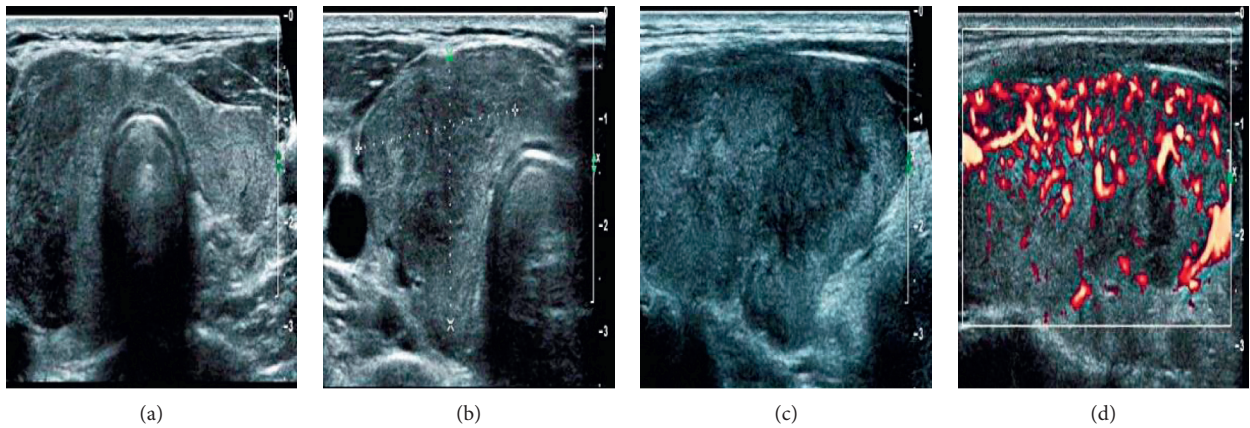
Conventional ultrasound and color Doppler ultrasound images of a 29-year-old male patient (ABC were conventional ultrasound images; C was a color Doppler image).
